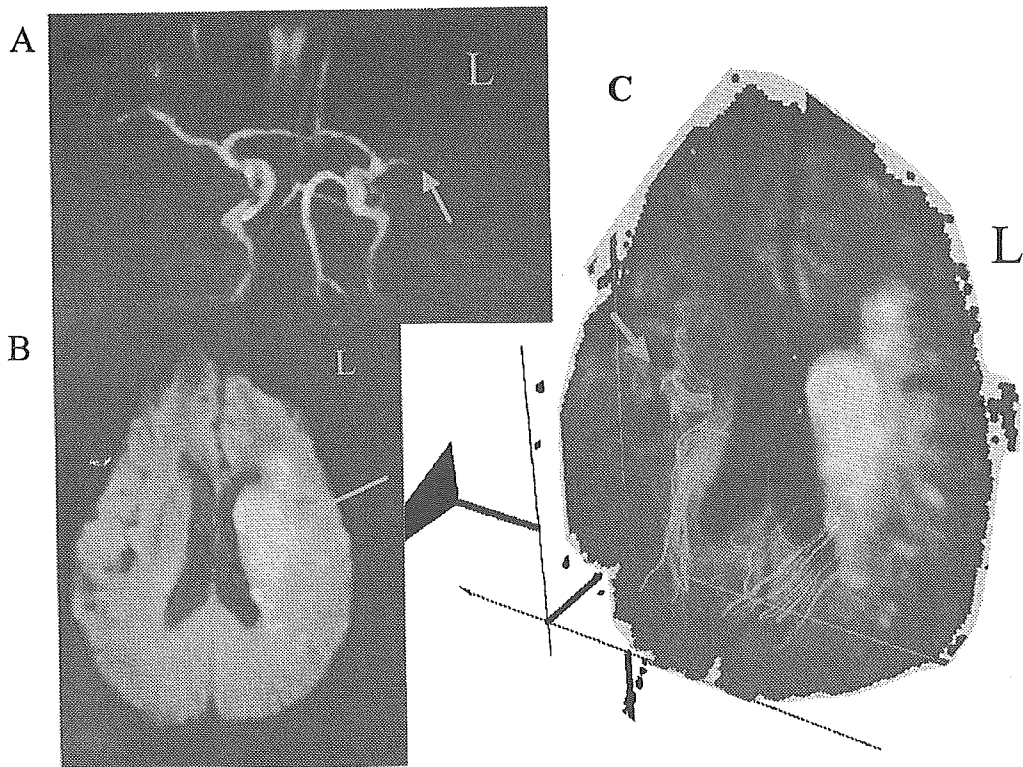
72歳 男性 左中大脳動脈閉塞症例の DWI と tractography
